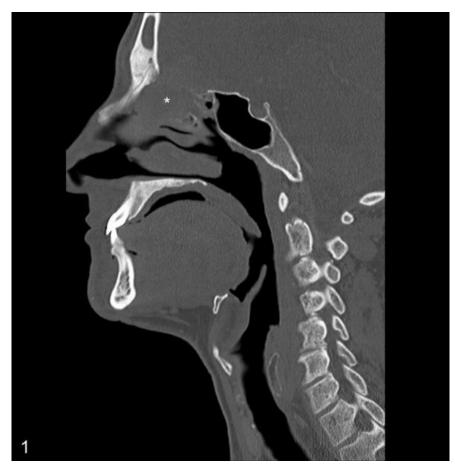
Sagittal CT bone algorithm image of a squamous cell carcinoma in the ethmoid sinus (asterisk) that has eroded the overlying floor of the anterior cranial fossa. ⁽¹⁶⁾
